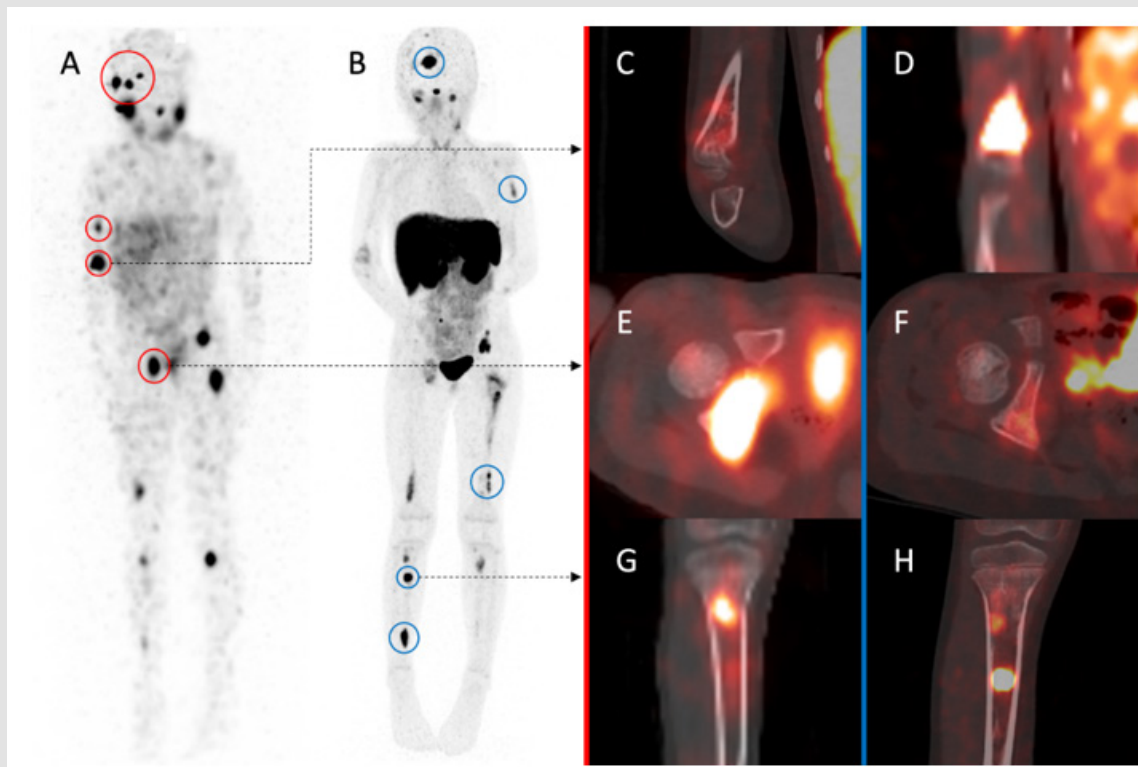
Anterior planar view of ¹²³I-mIBG scintigraphy (A) and maximum intensity projection of ⁶⁸Ga-DOTATOC PET-CT (B) revealing bone foci mismatch, some lesions presenting with high ¹²³I-mIBG uptake but lower than liver ⁶⁸Ga-DOTATOC uptake (red circles), while others presented with no or low ¹²³I-mIBG uptake and high ⁶⁸Ga-DOTATOC uptake (blue circles). Fused ¹²³I-mIBG SPECT/CT (red lined column) and ⁶⁸Ga-DOTATOC PET-CT (blue lined column) displaying noticeable mismatch on right distal humerus (C and D respectively, coronal view), right acetabulum (E and F respectively, axial view) and right tibia (G and H respectively, coronal view).
